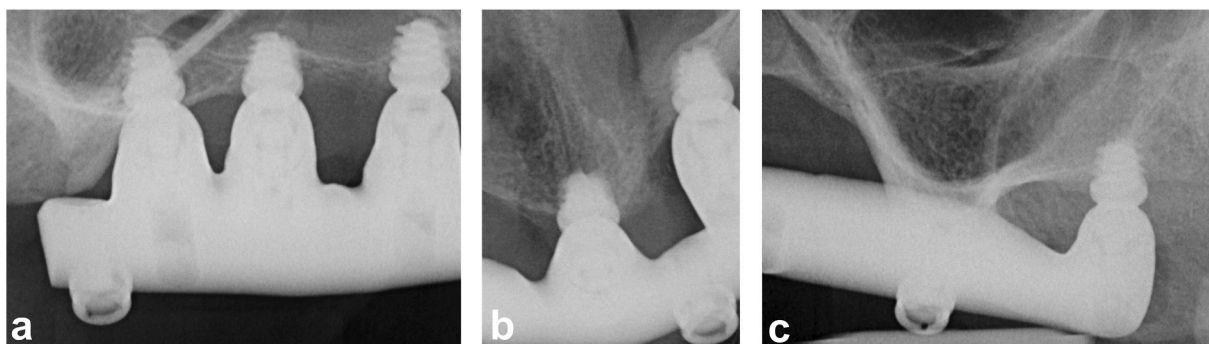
(a–c): Intraoral periapical x-rays taken 1 year after loading with stable peri-implant marginal bone levels.
